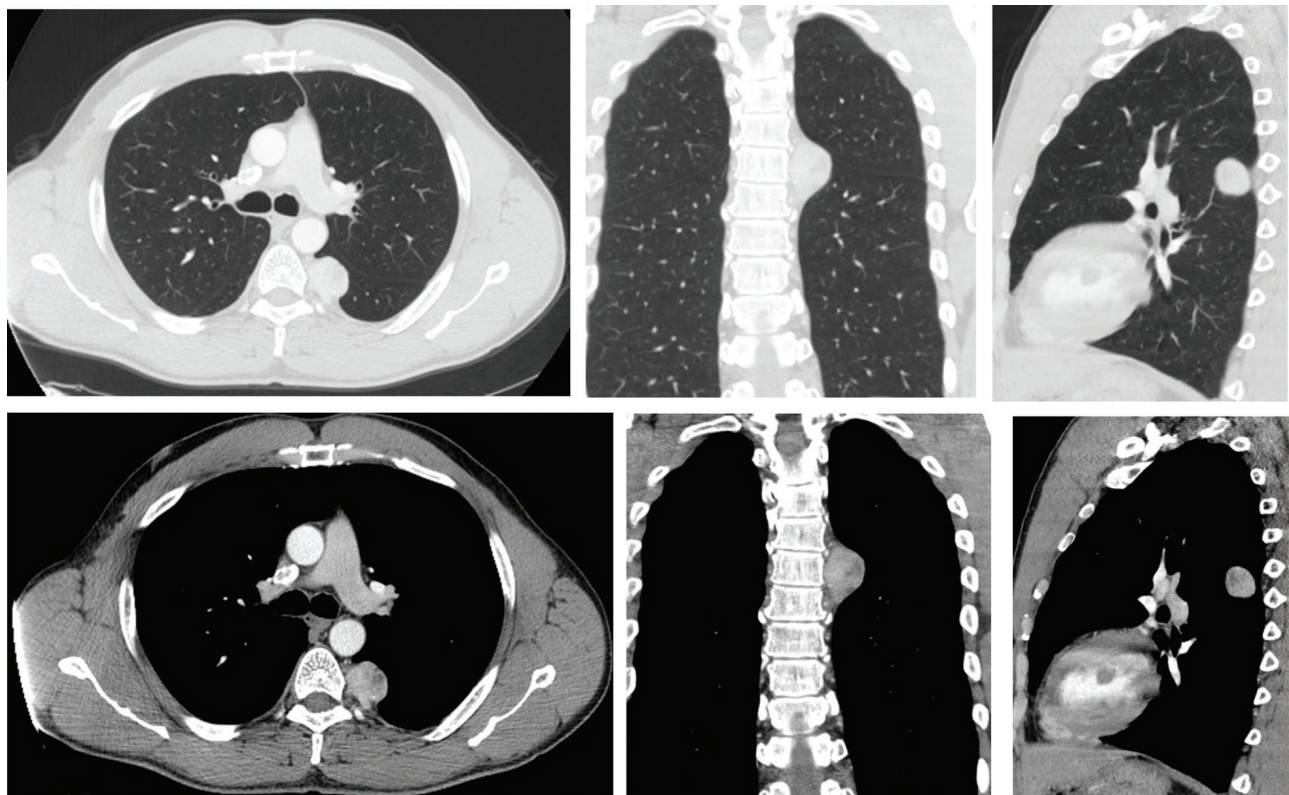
Contrast-enhanced CT Chest. Axial, coronal and sagittal images of the chest on lung and soft tissue windows reveal a pleural-based soft tissue density nodule in the posterior left hemithorax at the level of the carina
